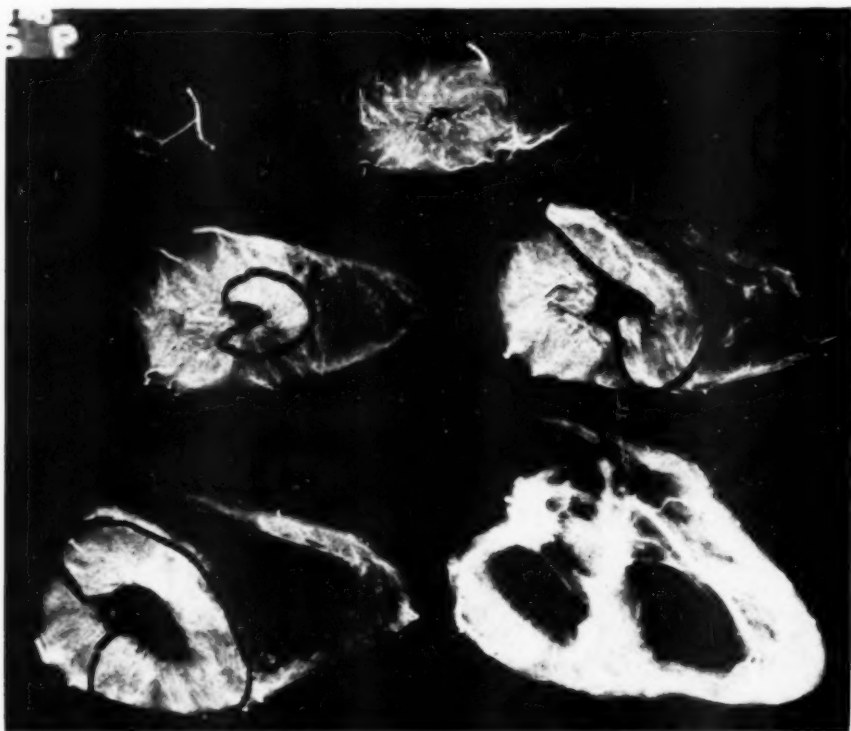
Roentgenogram of the heart of Case 12, showing position of infarct in black outline.
